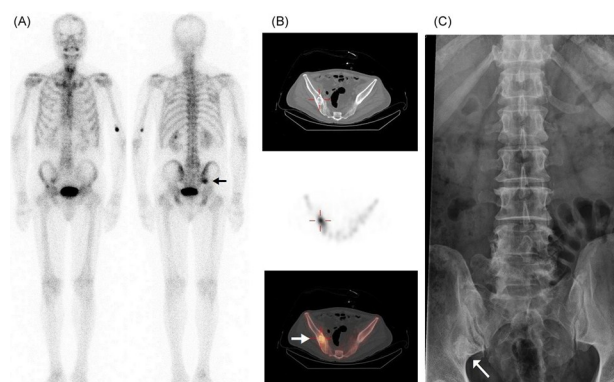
(A) The planar bone scan: a hot spot in lower portion of right ilium. (B) The SPECT/CT images: various ossification and cystic formation over right ilium on the reference CT images. (C) This finding was not pointed out on the first interpretation of the previous lumbar spine radiography performed 3 years ago from another hospital.
